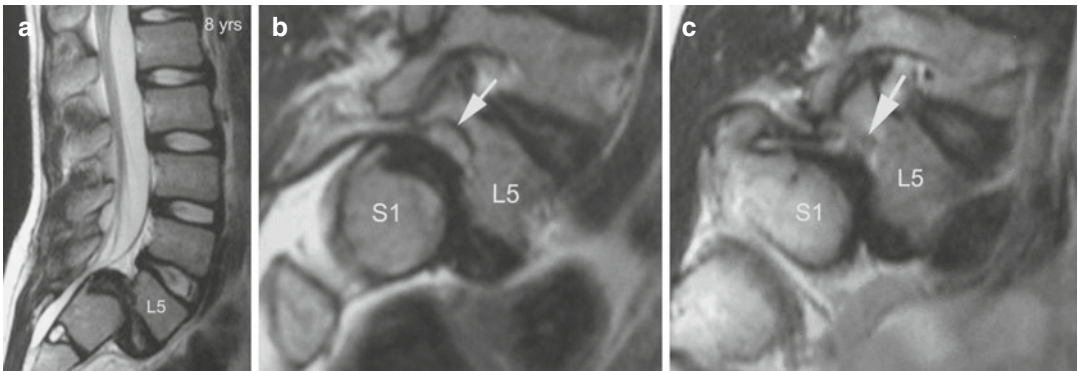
(a) Midsagittal lumbar MR image in high-grade spondylolisthesis. The central spinal canal is narrowed; the L5-S1 disc is severely damaged, (b, c) Right
